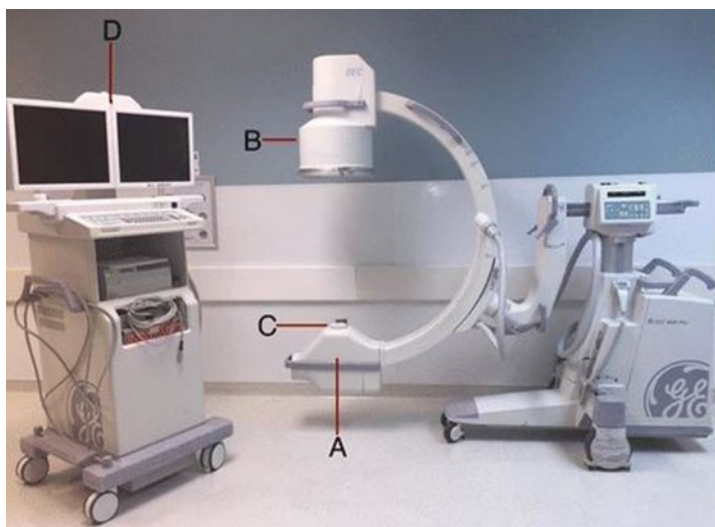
Mobile C-Arm used in angiography; A X-ray Tube; B Image Intensifier; C Collimator; D Display Monitor. Reprinted with open access permission Ref. [48]
